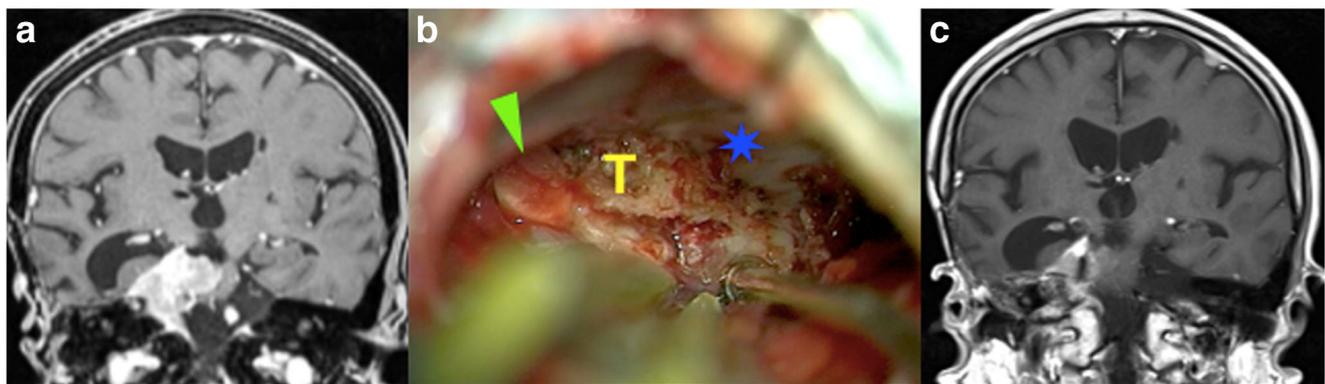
a Preoperative gadolinium-enhanced MRI of a patient with a relapse of petro-tentorial meningioma treated earlier with surgery (via a subtemporal approach) and radiotherapy. b Intraoperative view. Retrosigmoid approach with the patient in the *Dormeuse* position. Note
